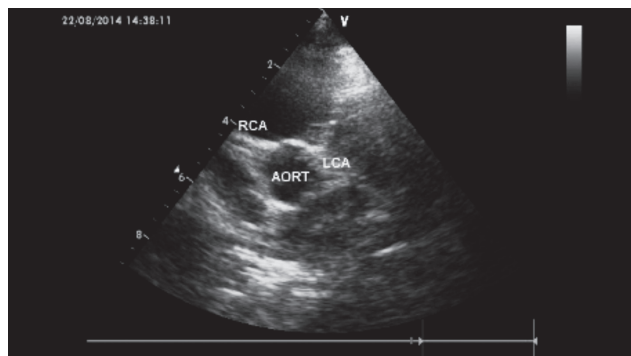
Echocardiography showing increased thickness of coronary artery walls especially right coronary artery
